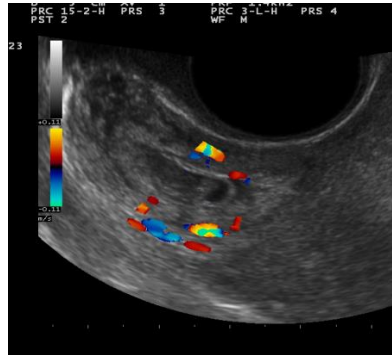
shows post-feticide Doppler ultrasound scan with no fetal cardiac activity
